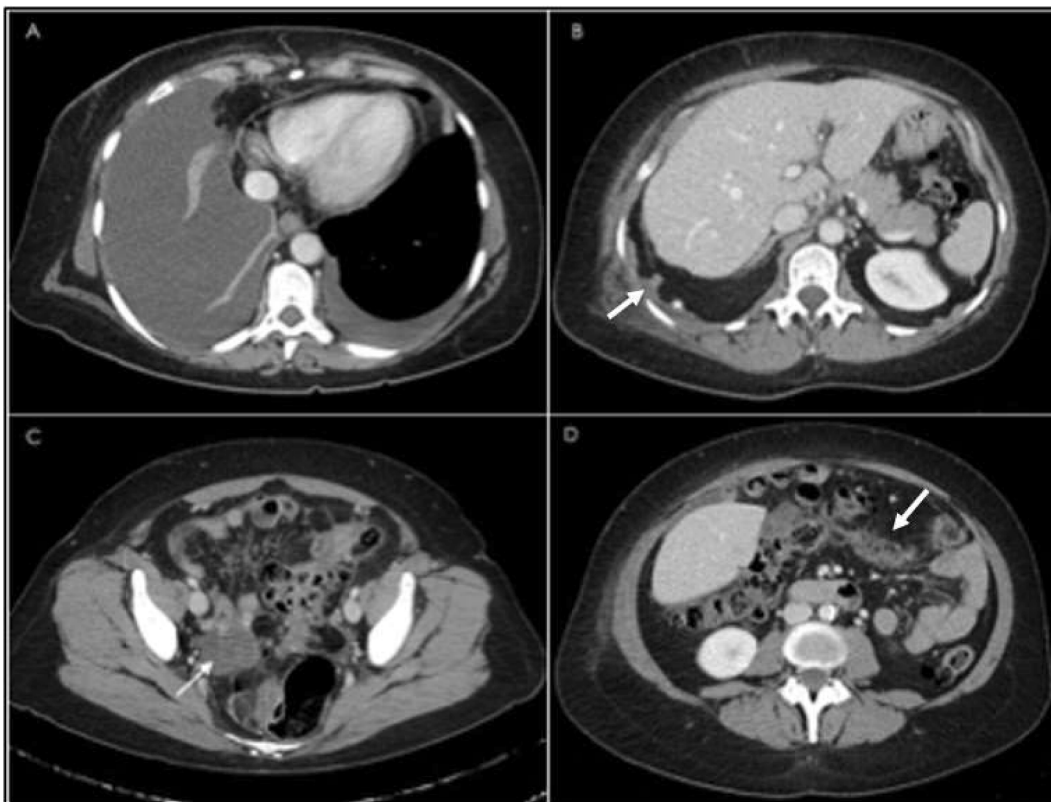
Computed tomography (CT) imaging at initial presentation (A) Significant right pleural effusion. (B) Peritoneal metastases on the right diaphragmatic dome (arrow). (C) Complex right ovarian mass (arrow). (D) Peritoneal metastases on the omentum (arrow).
